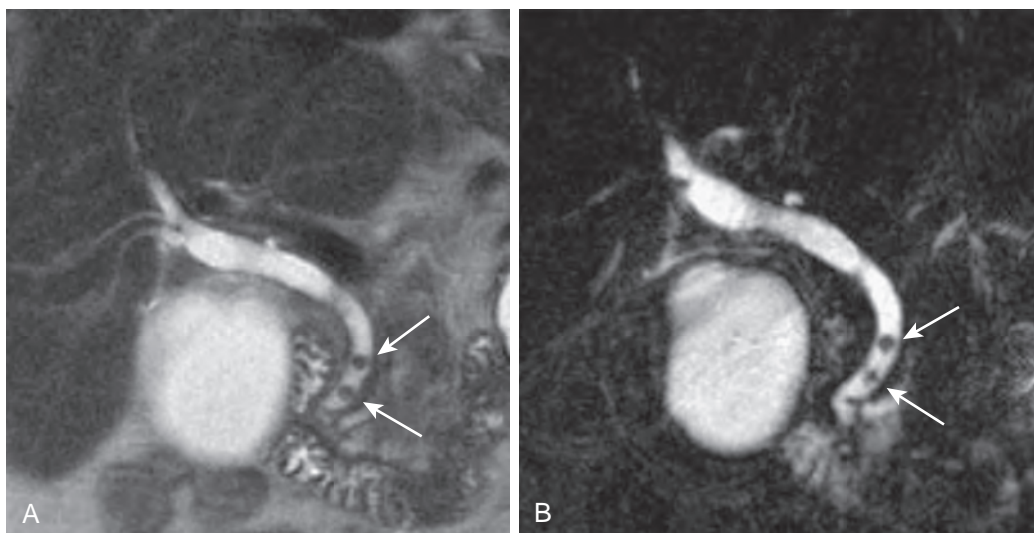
Choledocholithiasis: MR findings. A. T2-weighted coronal HASTE image shows low signal intensity CBD stones (arrows). B. Two-dimensional thick-slab image demonstrates stones (arrows).
